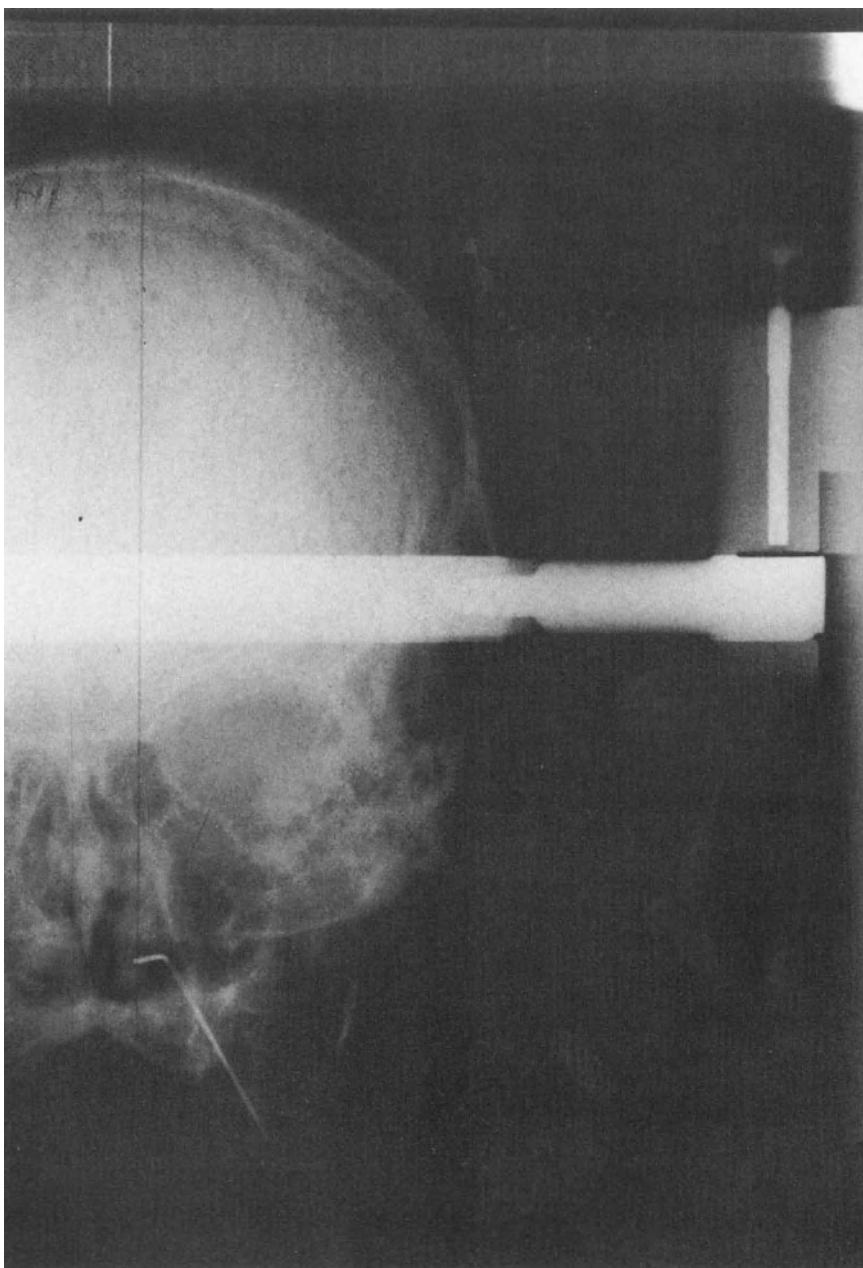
AP radiograph showing perpendicular projection through odontoid to horizontal ruler.
